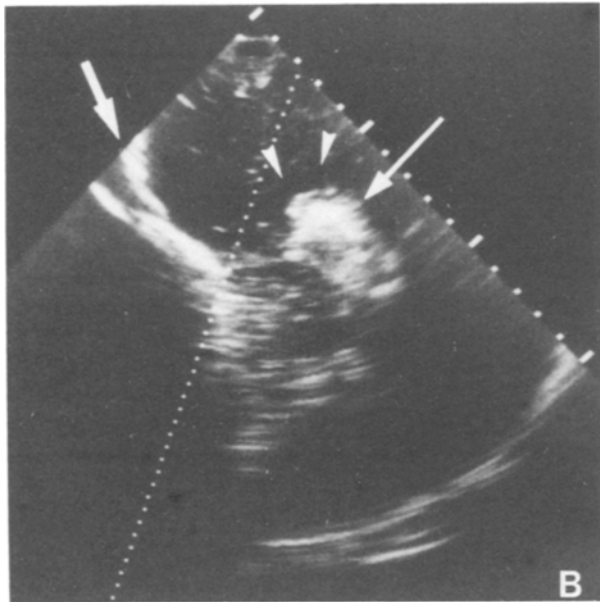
30-year-old male with an intraventricular oligodendroglioma. (A) Pre-operative enhanced computed tomography scan. An intraventricular tumour with irregular calcification is shown. (B) Sagittal-cut ultrasonic image through a burr-hole shows the tumour. Front of head is on the left side of the image. The transducer could not be tilted enough for the dotted guideline to coincide with the tumour (*thin arrow*). The anterior horn (*small arrowheads*) and the frontal skull base (*arrow*) are seen. (C) Sagittal-cut ultrasonograph through a small craniotomy shows the guideline passing through the tumour (*thin arrow*). Front of head is on the right side of the image. The biopsy through the needle-guide established the diagnosis of oligodendroglioma. Frontal skull base (*arrow*), occipital skull convexity (*arrowheads*), and the anterior horn (*small arrowheads*) are seen
